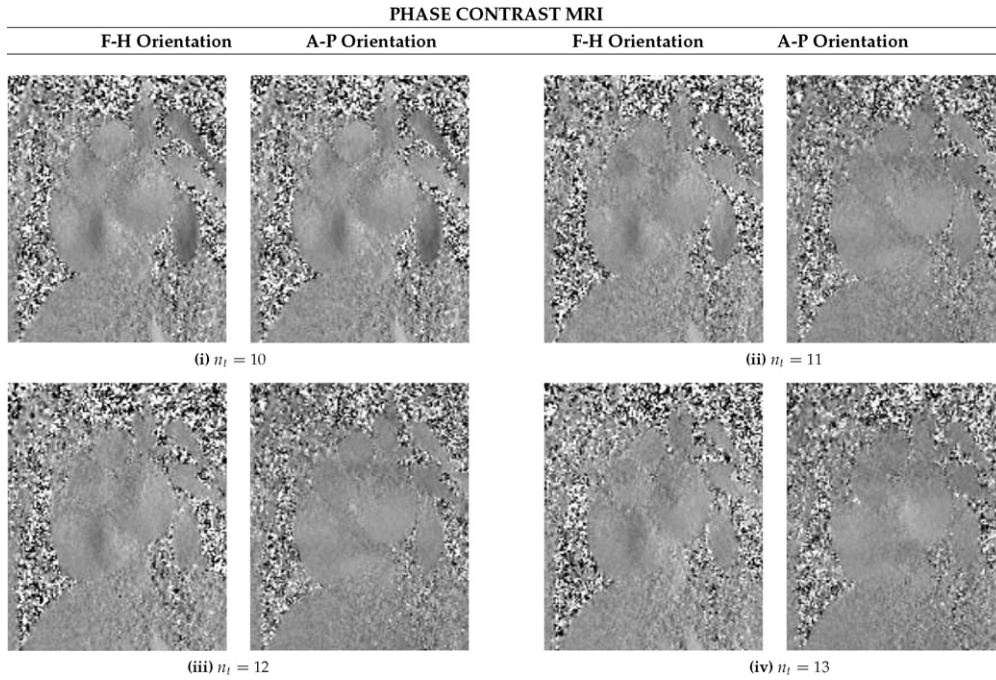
Phase contrast MRI of a cardiac chamber. Short axis scans pertaining to time frames $n_t = [10, 11, 12, 13]$ out of 25 frames in a cardiac cycle are presented. Scans based on two in-plane x- and y-directions, which pertains to the foot–head (F–H) and the anterior–posterior (A–P) orientations, respectively, are needed for velocity mapping. The intensity of the pixels in the image indicates the magnitude of the velocity component in the specified orientation. Combining two orthogonal velocity-encoded image maps can produce a two-dimensional velocity flow field.
